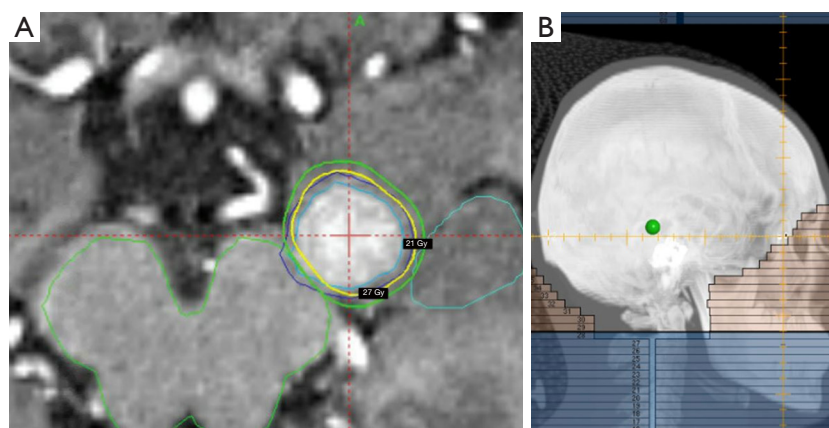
A 16-year-old male with metastatic osteosarcoma. The patient presented with headaches and seizures. Three intra-axial enhancing brain metastases were seen on contrast-enhanced brain MRI. All three lesions were treated with fractionated cobalt-60 stereotactic radiotherapy, 27 Gy in 3 fractions (prescribed to the 50% isodose line), using a relocatable frameless mask system. (A) SRS to the left temporal lesion is shown in the left panel. The thin cyan line represents the gross tumor volume. The dark blue line represents a 1 mm planning tumor volume. The 27 and 21 Gy isodose lines are shown in yellow and green, respectively. The brainstem and left hippocampus are delineated using thin green and teal lines, respectively. (B) The patient developed more than 12 new metastases on repeat MRI brain, 10 weeks after SRS. The patient subsequently received 20 Gy in 5 fractions whole brain radiotherapy, as shown. MRI, magnetic resonance imaging; SRS, stereotactic radiosurgery.
